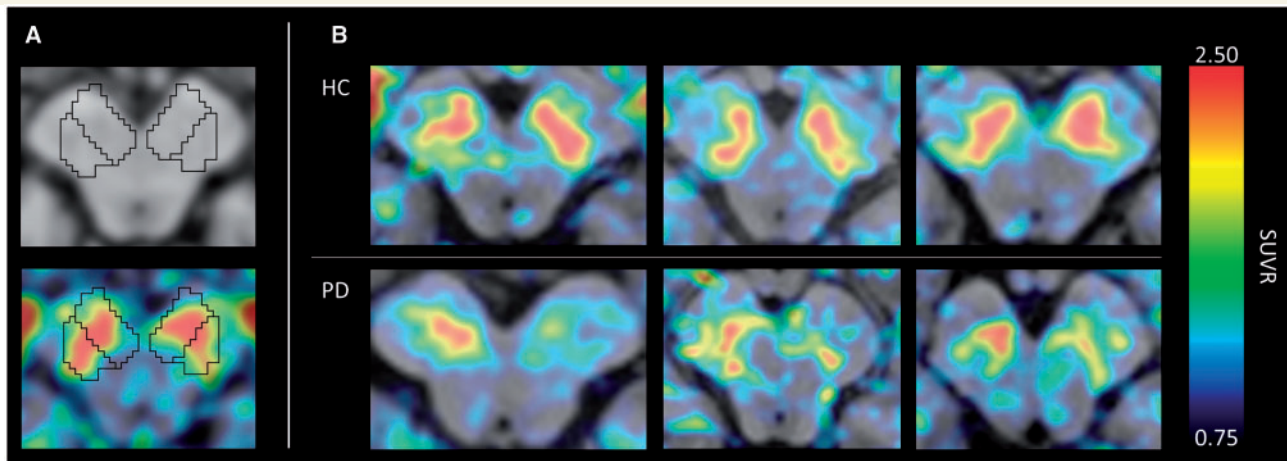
^{18}F -AV-1451 PET images of the substantia nigra. (A) Automated midbrain volumes of interest superimposed on magnetic resonance (top) and fused PET/magnetic resonance images (bottom) of a 76-year-old female control (minimum substantia nigra V_d 0.95 ml). (B) Six representative fused PET/magnetic resonance examples. Healthy controls (HC), top row from left: 68-year-old male (minimum substantia nigra V_d 0.61 ml), 73-year-old male (minimum substantia nigra V_d 0.68 ml), 72-year-old male (minimum substantia nigra V_d 0.92 ml). Parkinson's disease (PD); bottom row from left: 66-year-old female minimum (substantia nigra V_d 0.35 ml), 57-year-old male (minimum substantia nigra V_d 0.49 ml), 65-year-old male (minimum substantia nigra V_d 0.58 ml), all Hoehn and Yahr stage II. Colour scale shows SUVR with cerebellum as reference.
